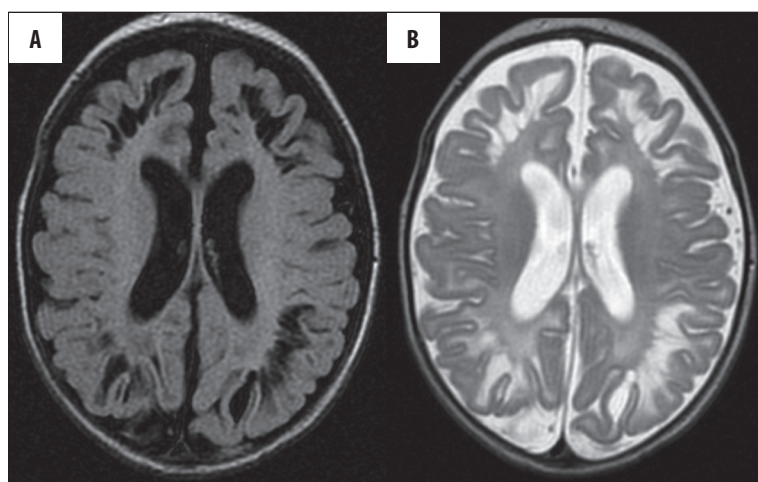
Multicystic encephalopathy in a 5-week-old child, visible despite therapeutic hypothermia. (A) FLAIR,ax; (B) FSE/T2,ax.
